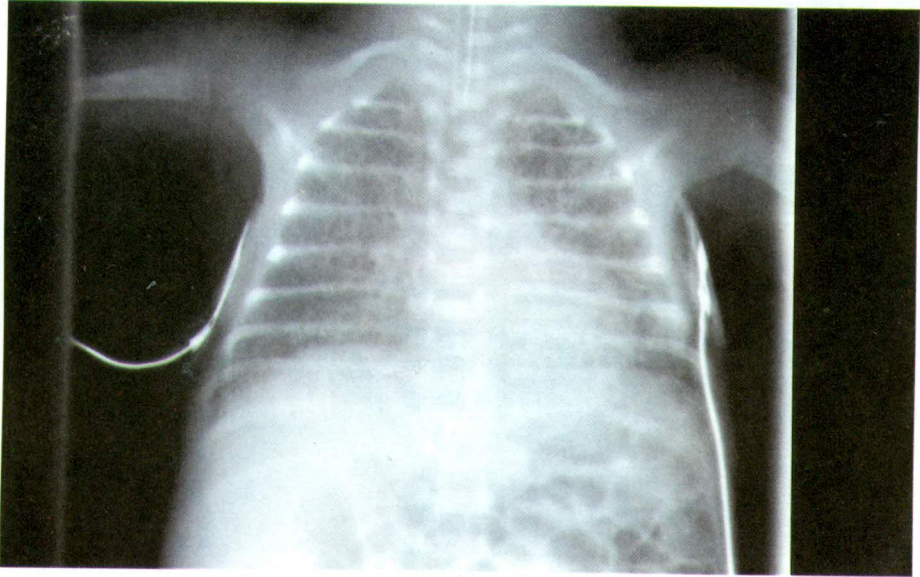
Preoperative chest X-ray showing marked cardiomegally (patient is intubated).
